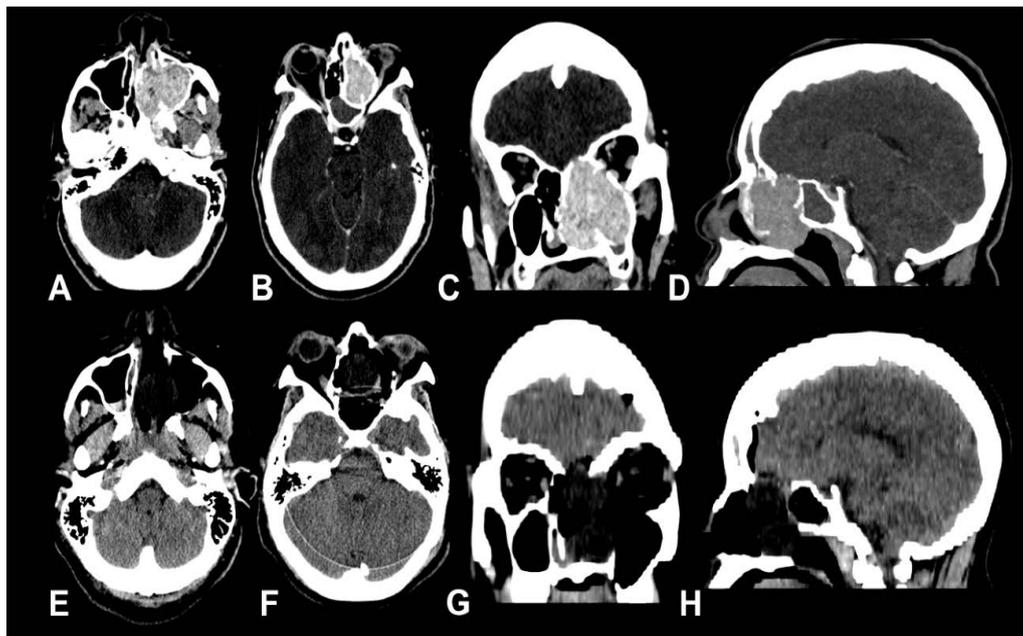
Pre- and postoperative post-contrast CT scans. A: axial preoperative CT scan showed the maxilar sinus extension. B: axial preoperative CT scan showed the extraconal orbital apex extension. C: preoperative coronal reconstruction showed the anterior cranial base erosion. D: sagittal preoperative reconstruction showed the anterior cranial base inclusion and the spared frontal and sphenoid sinuses. E, F, G, H: postoperative images exhibited the completely resection of the lesion including safe oncological margins (anterior cranial base, papiracea, nasal septum and ethmoid box).
